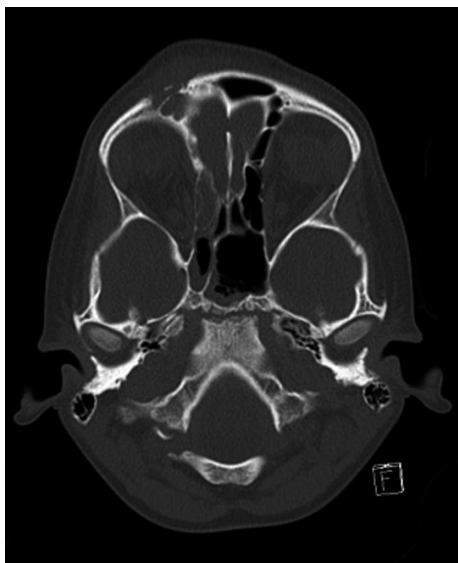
Axial computed tomography (CT) image with sinus opacification, frontal bone erosion and forehead swelling.
